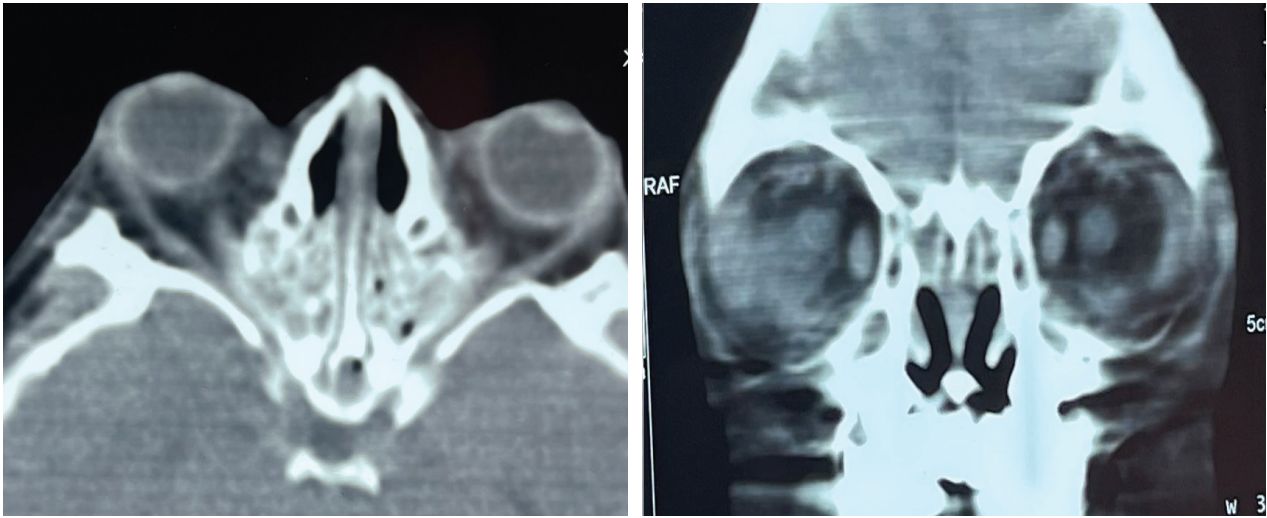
Preoperative Computed Tomography scan orbit (axial and coronal).
